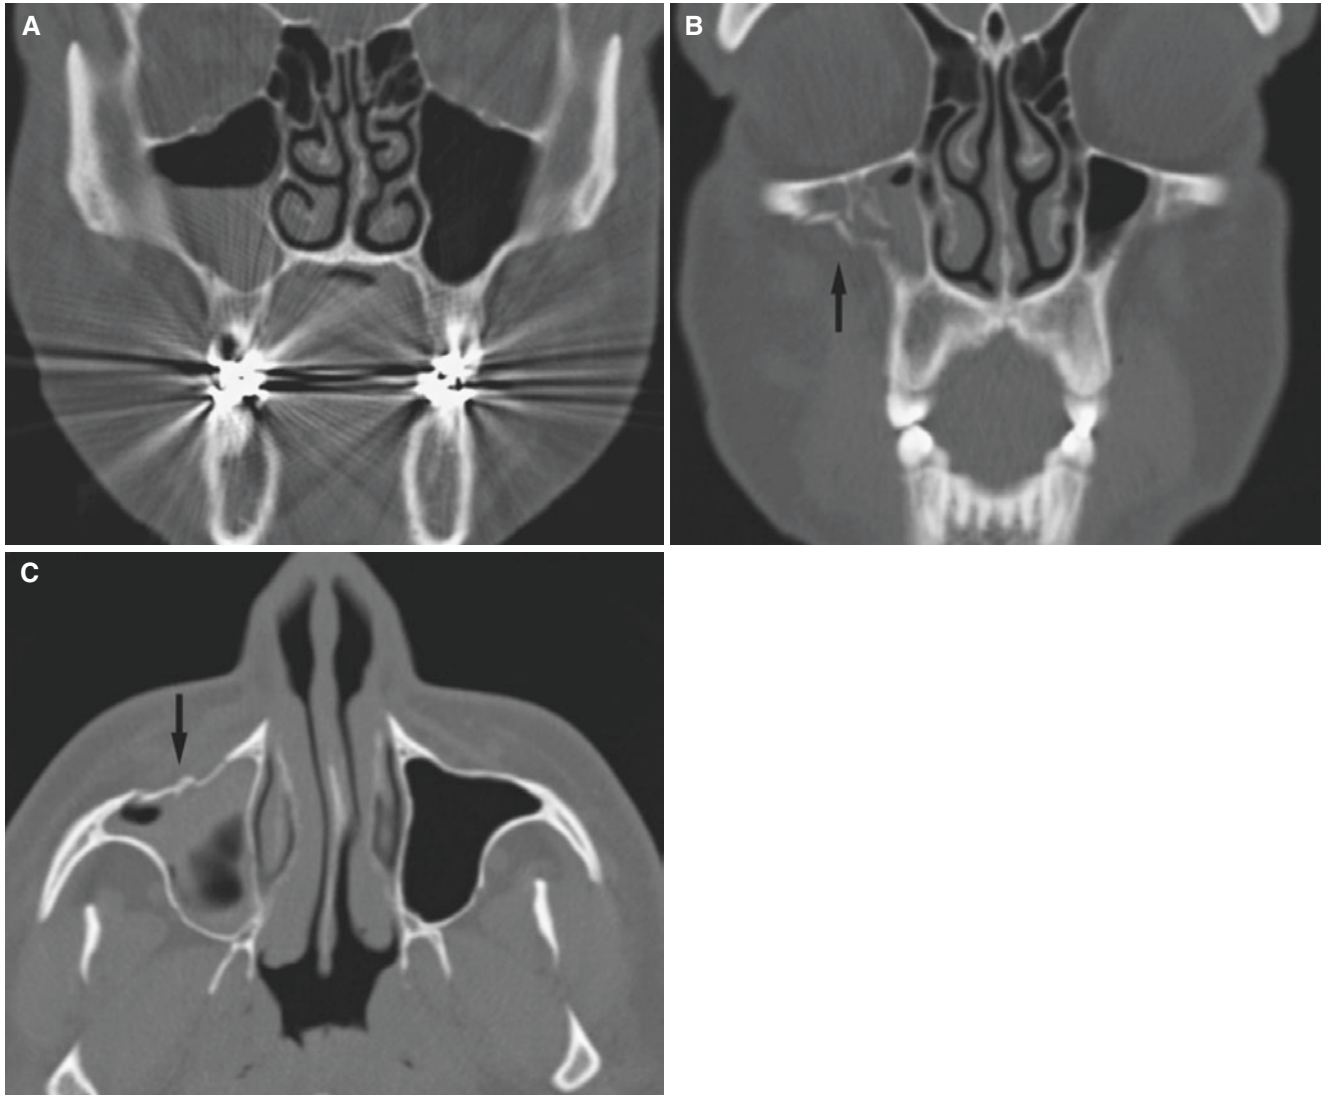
Maxillary sinus wall fracture; 32-year-old male victim of violence 3 days previously, with infraorbital hematoma and pain. (A) Coronal CT image shows normal bony walls of maxillary sinuses but
